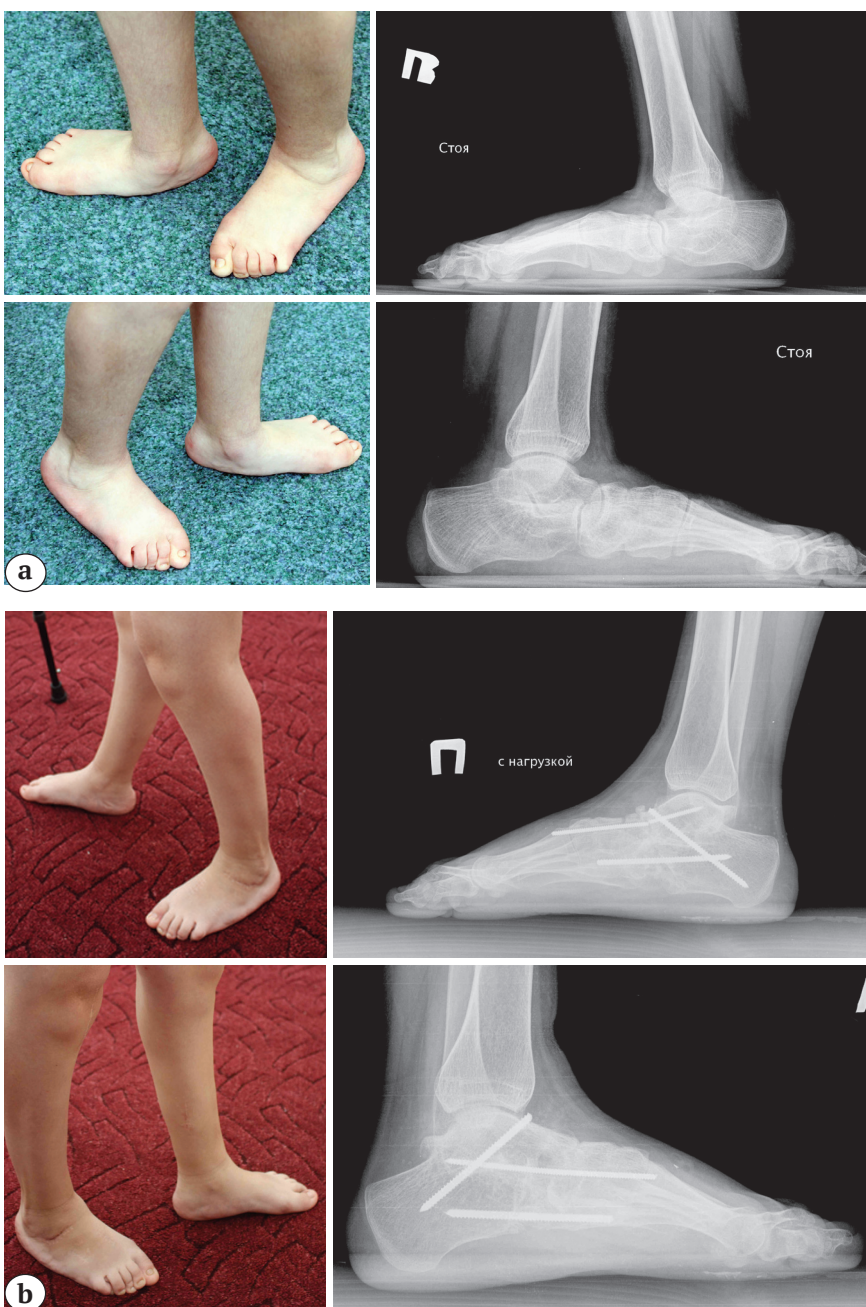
Image and X-ray of patient of 15 y.o.:
